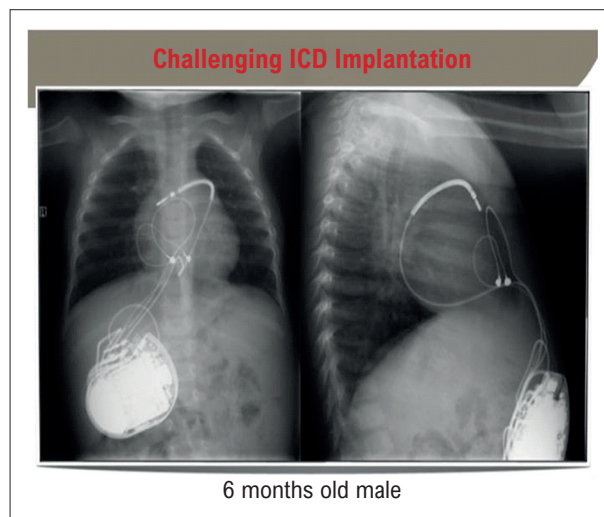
Chest X-ray of the abdominal implant of an ICD in a 6-month old baby. The shock electrode is located in the transverse sinus with the distal electrode screwed into the right atrium. Two epicardial electrodes are placed to detect and stimulate the free wall of the right ventricle. The system is completely extravascular with all of the benefits of an ICD DDD. Algorithms of DDD discrimination, detection, and stimulation, as well as anti-tachycardia stimulation, in contrast to the subcutaneous ICD, are fully available.
